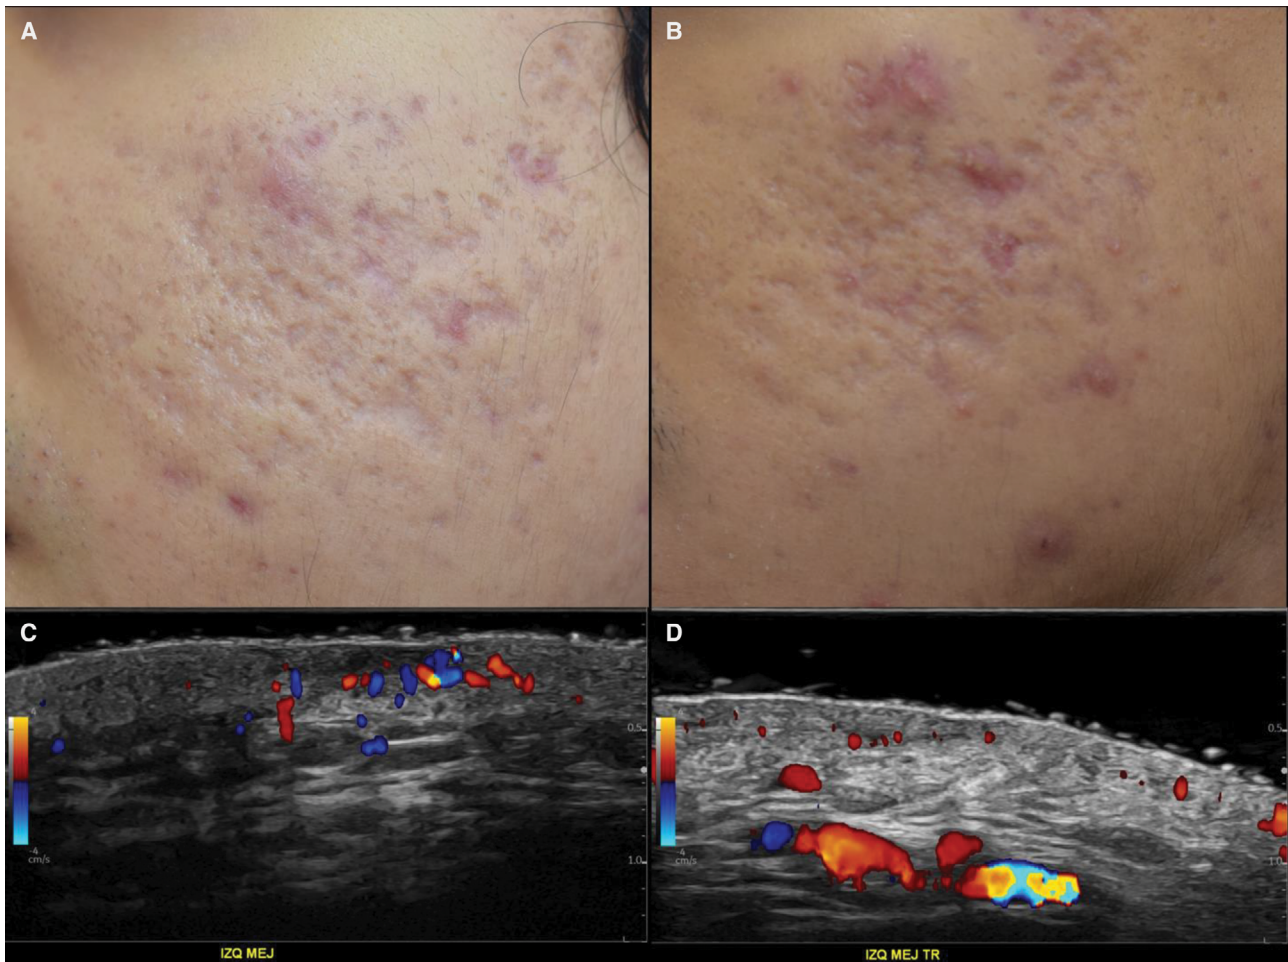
Effects on the left cheek with microneedling. (A) Baseline clinical image; (B) Follow-up clinical image at 3 months. Clinically, there is a decrease in the depths of acne scars. Color Doppler high-frequency ultrasound at 24 MHz: baseline (C) and follow-up (D). Notice the decrease in the degree of vascularity (colors) at follow-up.
